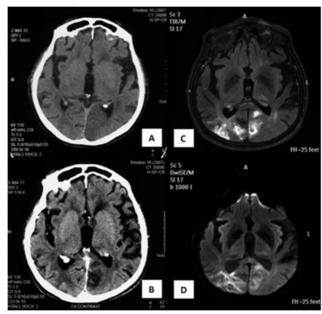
A-D. Emergency CT without contrast agent (A) and follow up CT with contrast agent (B) showed evidence of ischemic lesions in progress in the left occipital lobe. FLAIR MRI (C) and DWI MRI (D) showed areas of increased signal intensity in both occipital regions, suggestive of ischemia.
